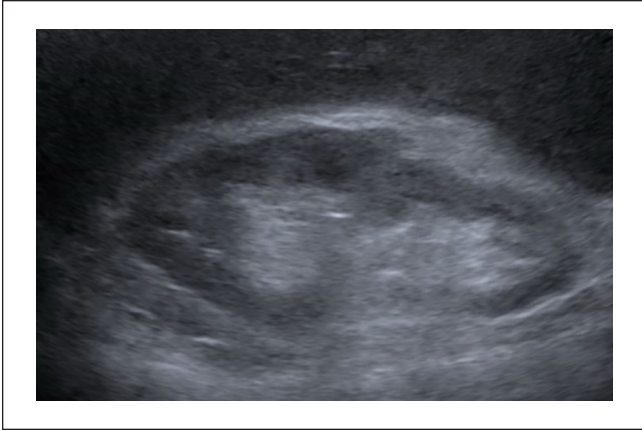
Ultrasound of right kidney, which measures $10.4 \times 4.3 \times 4.4$ cm. There is minor renal cortical thinning asymmetrically involving the mid-pole cortex. The cortex is mildly hyperechoic. No sonographic evidence of calculus or ureteral dilatation.
